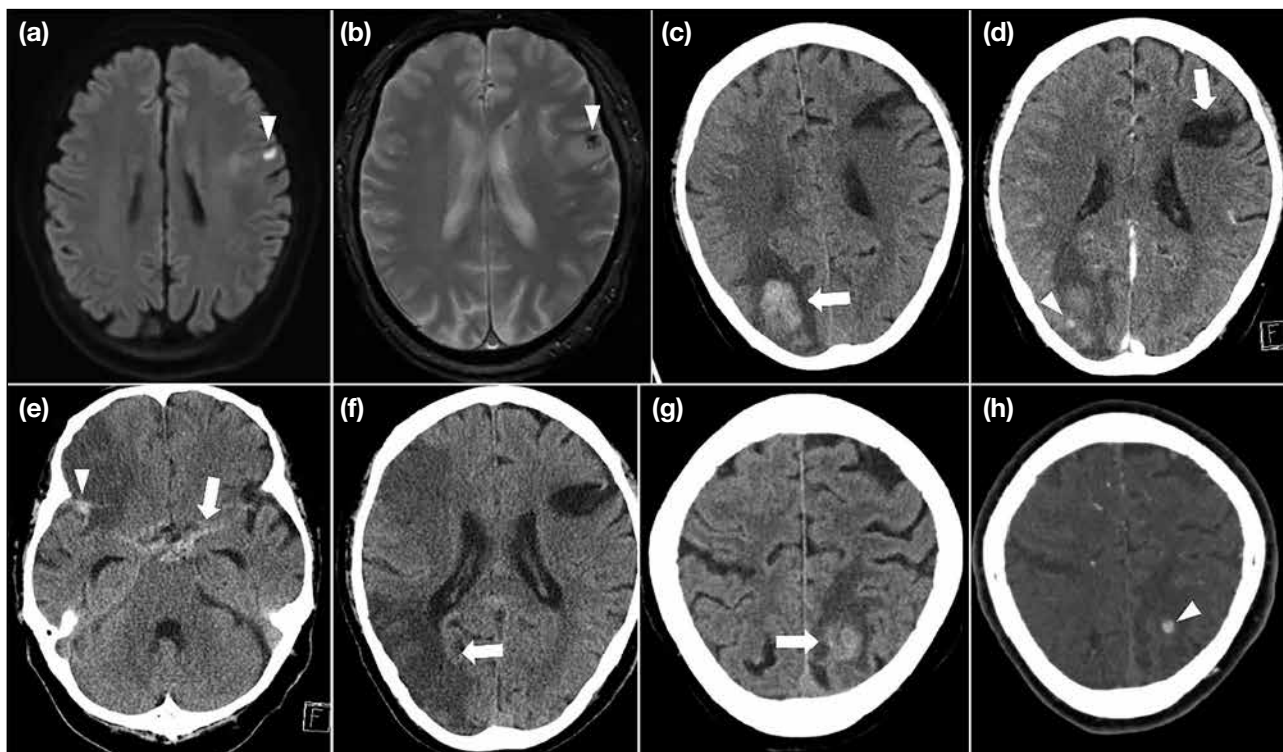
A 62-year-old man with known mitral valve regurgitation. (a) Axial diffusion-weighted imaging of the brain with a high b-value shows a focal hyperintense signal in the left frontal lobe (arrowhead), with corresponding hypointensity on the apparent diffusion coefficient map (not shown). (b) Associated susceptibility artefact is noted in the same region (arrowhead), suggestive of haemorrhagic transformation. (c) Axial unenhanced computed tomography (CT) of the brain 1 month later shows a new haemorrhagic infarction in the right occipital lobe with mild perilesional oedema (arrow). (d) Axial computed tomography angiography (CTA) of the brain shows a tiny contrast-enhancing focus within the haemorrhagic infarct, suggestive of an aneurysm (arrowhead), while the left frontal infarct shows signs of chronicity (arrow). (e) Axial non-contrast CT of the brain 1 day later shows a new right frontal lobe infarct, as well as new subarachnoid haemorrhage in the right frontal region (arrowhead) and suprasellar cistern (arrow). (f) Axial non-contrast CT of the brain 3 days later reveals a new right parieto-occipital lobe infarct (arrow). (g) Axial non-contrast CT of the brain 1 month later shows a new haemorrhagic infarct in the high left parietal lobe (arrowhead). (h) Axial CTA of the brain shows a tiny contrast-enhancing focus (arrowhead) within the haemorrhagic infarct suggestive of aneurysm. The presence of multiple haemorrhagic infarcts of different timing, some with associated aneurysms, is highly suggestive of cerebral septic emboli with mycotic aneurysms. Subsequent echocardiography revealed mild mitral and tricuspid regurgitation with vegetations on both mitral valve leaflets. Blood cultures yielded *Rothia dentocariosa*. A diagnosis of infective endocarditis was established and the patient was treated with intravenous antibiotics.
